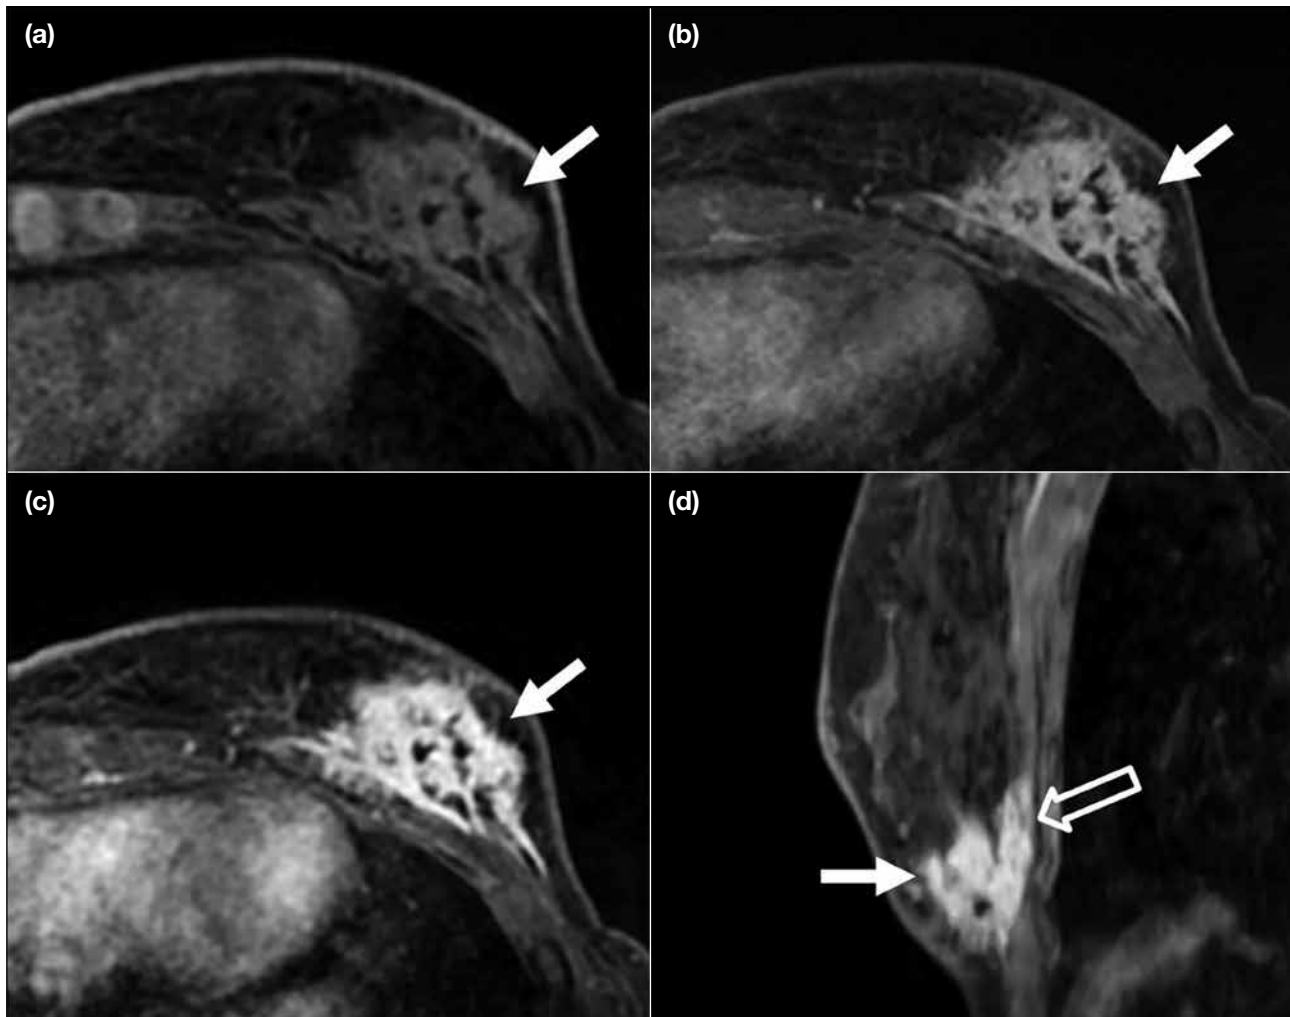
Magnetic resonance images. (a) Axial fat-saturated T1-weighted images showing an isointense lesion (arrow) at left 5 o'clock position, hyperintense on (b) axial fat-saturated water sensitive images (arrow). (c) Axial fat-saturated T1-weighted post-contrast image showing enhancement of the irregular lesion (arrow). (d) Sagittal T1-weighted fat-saturated post-contrast image showing the enhancing lesion (arrow) with underlying pectoralis muscle invasion (open arrow).
